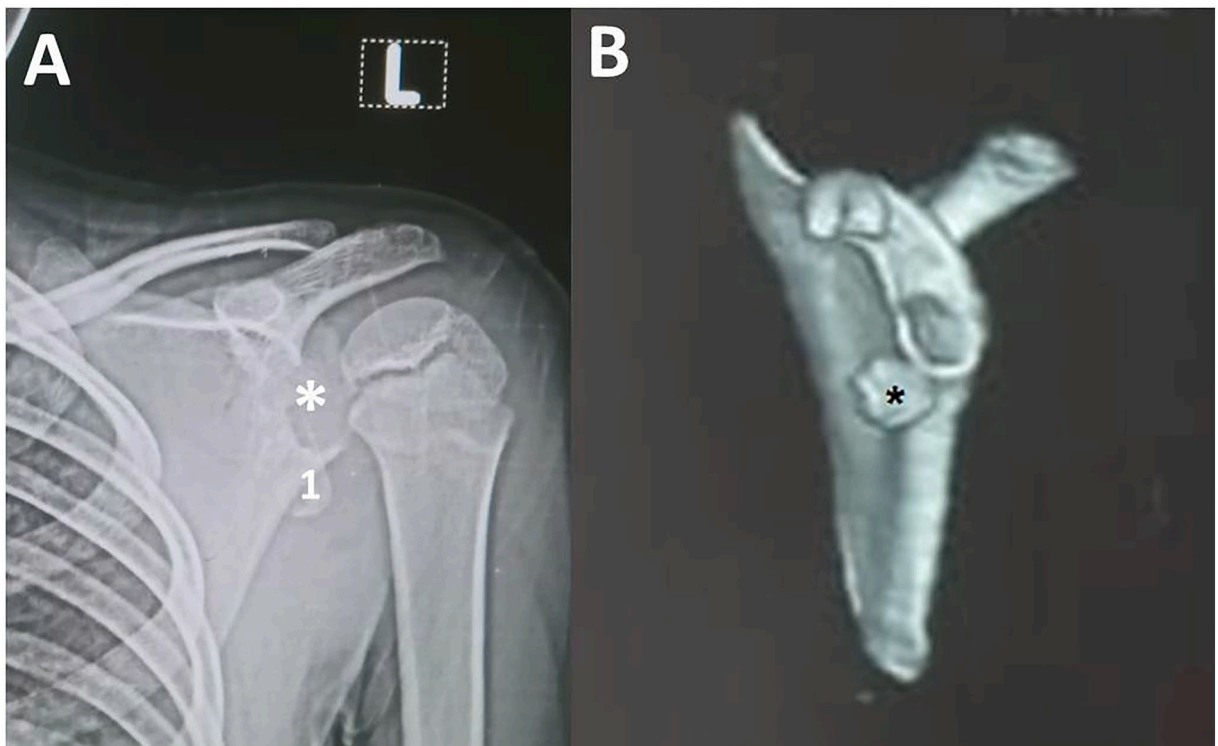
Preoperative imaging. A: Standard AP view of the left shoulder with evident anteroinferior glenoid defect marked (Star) and bone fragment marked (1). B: En Face 3D CT scan view of the left glenoid showing the anterior GLAD lesion. (Star).
